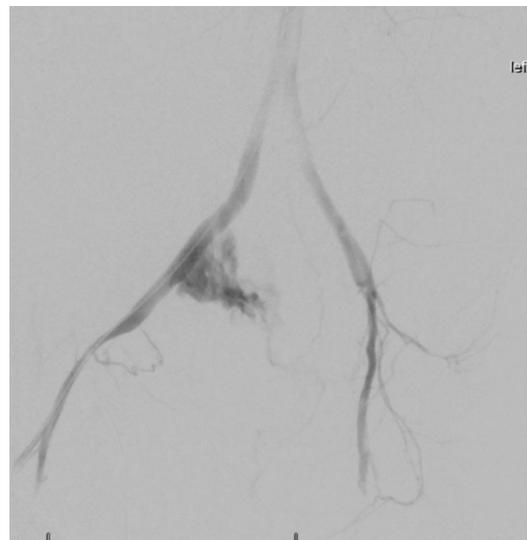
CT Aortography shows ruptured right common iliac artery aneurysm with contrast extravasation into the pelvis.
